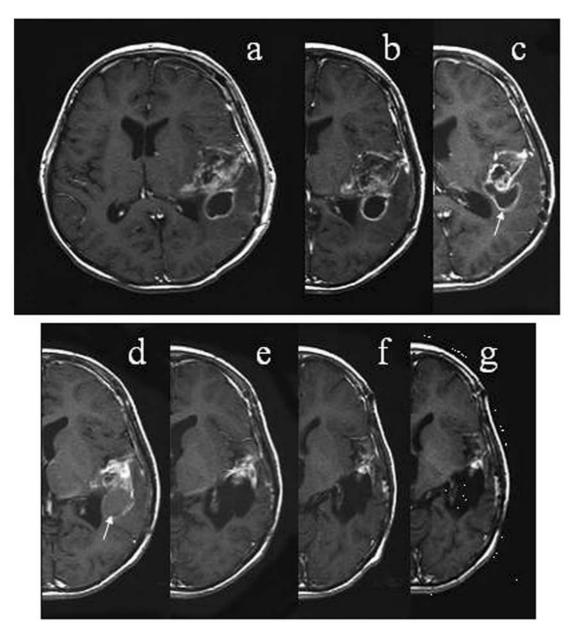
Follow-up MR images: a) immediately, b) 2, c) 4, d) 6, e) 8, f) 12, g) 36 months after discharge with fulfilment of surgical resection and irradiation. Arrows indicate hemorrhage in the post-operative cavity.
